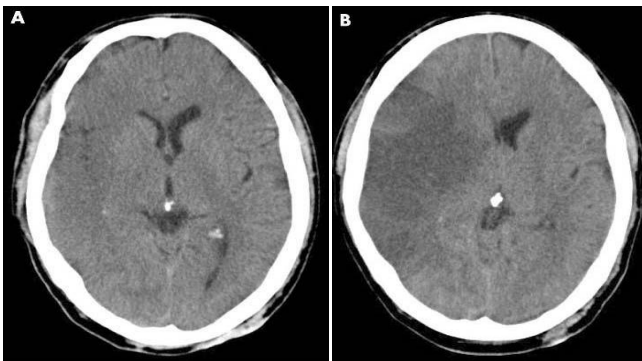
Evolution of hypodensity on computed tomography (CT) scan. (A) after 4 hours of stroke onset, right MCA ischemia and (B) 24 hours after stroke onset. First CT scan shows early ischaemic changes: loss of grey-white matter definition, lentiform nucleus hypodensity, loss of insular ribbon, compression of lateral ventricle, and hemispheric sulcal effacement [24].
